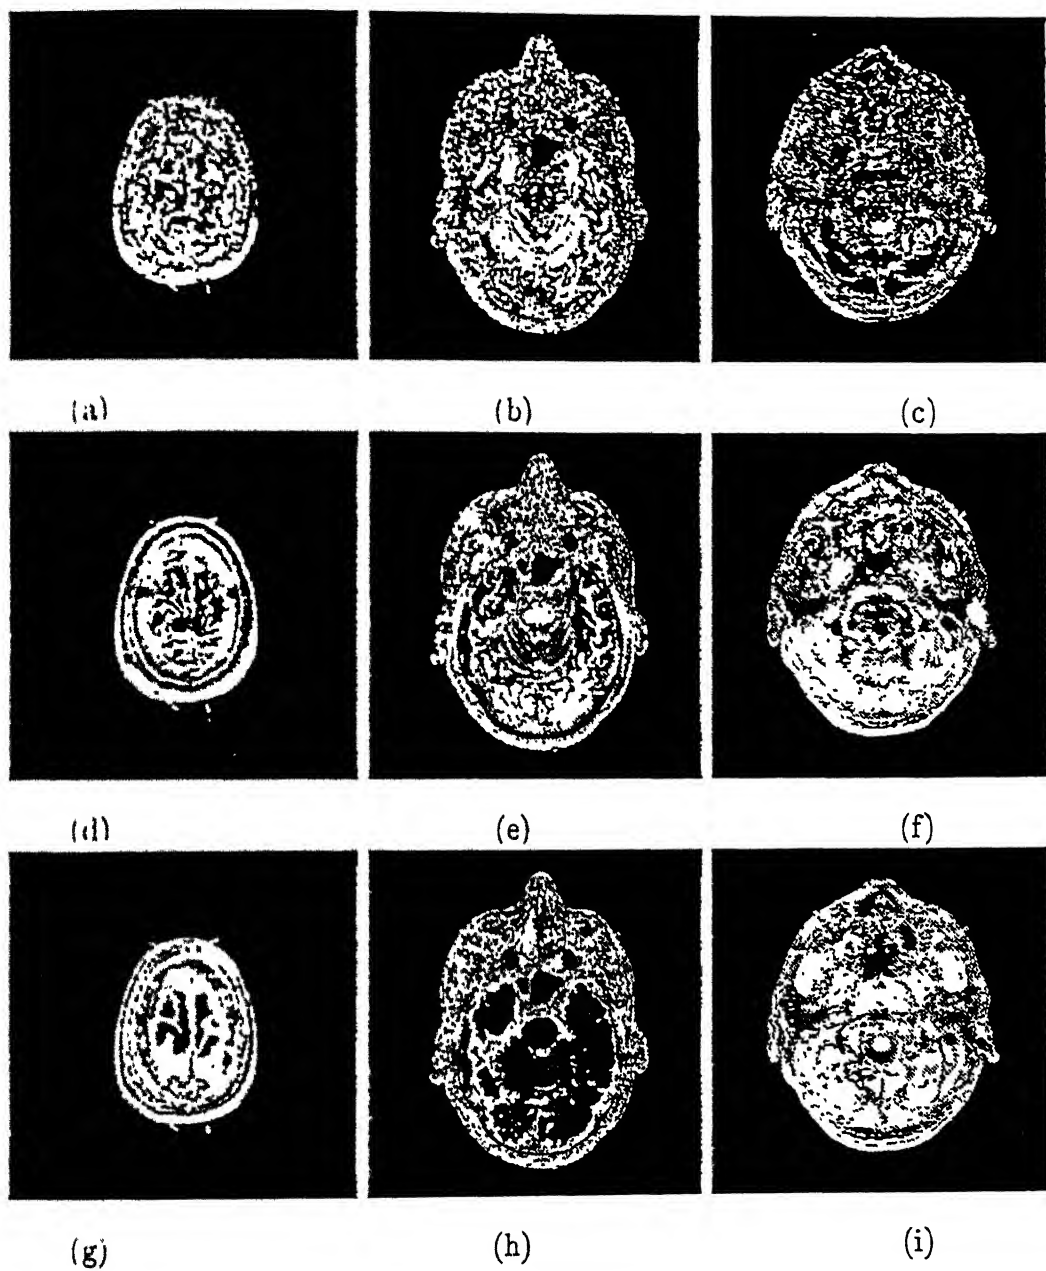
Selected Slices from MRI Data Set 2. (Top) PD-weighted. (Middle) T2-weighted. (Bottom) T1-weighted. (a),(d),(g) Slice 1. (b),(e),(h) Slice 8. (c),(f),(i) Slice 15.
